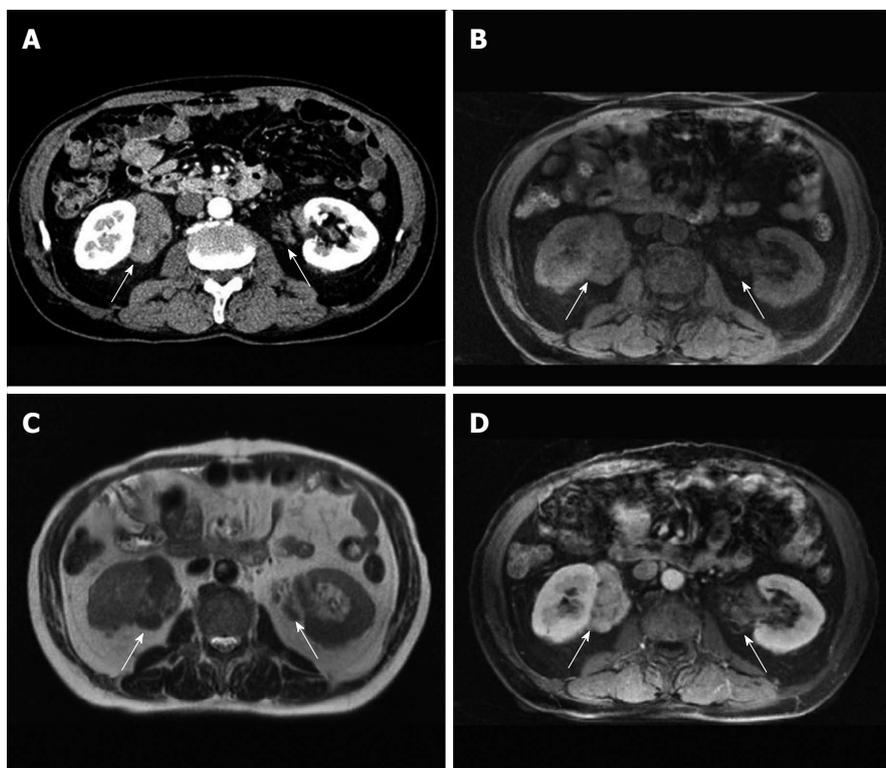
Localized pseudotumors (arrows) in a 67-year-old man with IgG4-related retroperitoneal fibrosis and autoimmune pancreatitis. A: Contrast-enhanced CT; B: T1-weighted; C: T2-weighted; D: Contrast-enhanced MRI.
